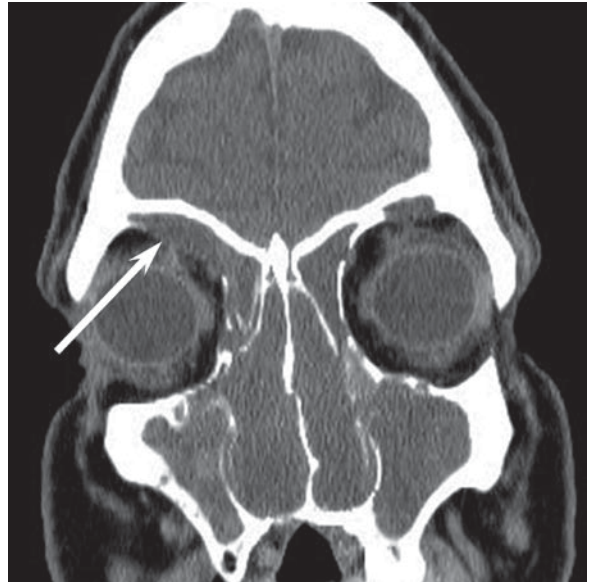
NP with frontal mucocele causing mass effect on the orbit. Coronal CT shows complete opacification of the nasal cavity and sinuses, consistent with NP. The frontal sinus is expanding into the orbit (*arrow*). The underlying bone is thinned beyond the resolution of this CT
